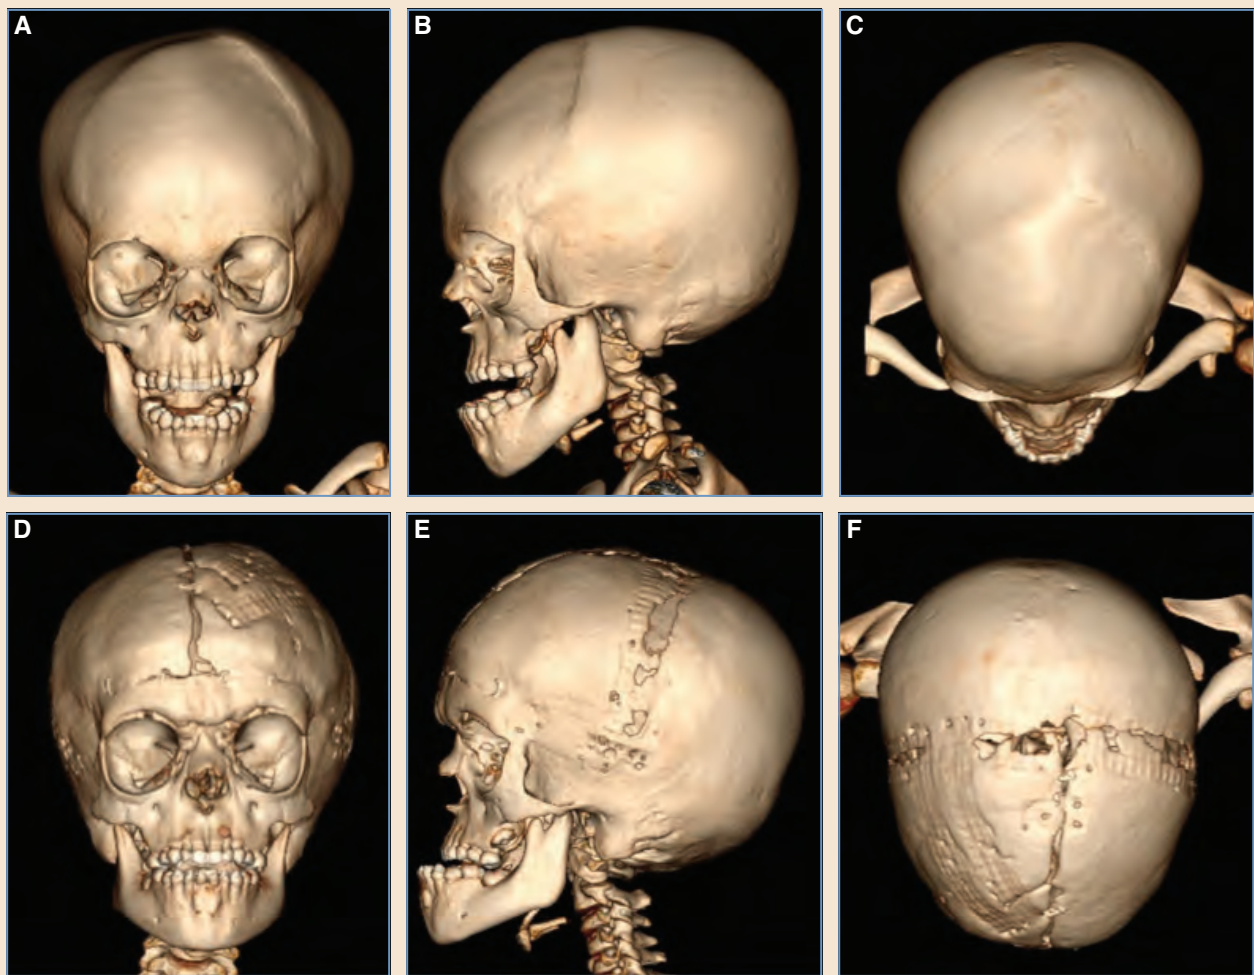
A-C, 3D reconstructions of a low-dose craniofacial CT scan obtained to aid diagnosis and preoperative planning for a 6-year-old male with Apert syndrome. The patient presented with pansutural craniosynostosis, resulting in papilledema and thumb-printing of the calvaria, suggestive of elevated intracranial pressure. D-F, 3D reconstructions of a low-dose craniofacial CT scan obtained 1 year after anterior cranial vault remodeling, frontoorbital advancement, and frontal sinus obliteration. The patient also had midface hypoplasia and shallow orbits characteristic of Apert syndrome.
